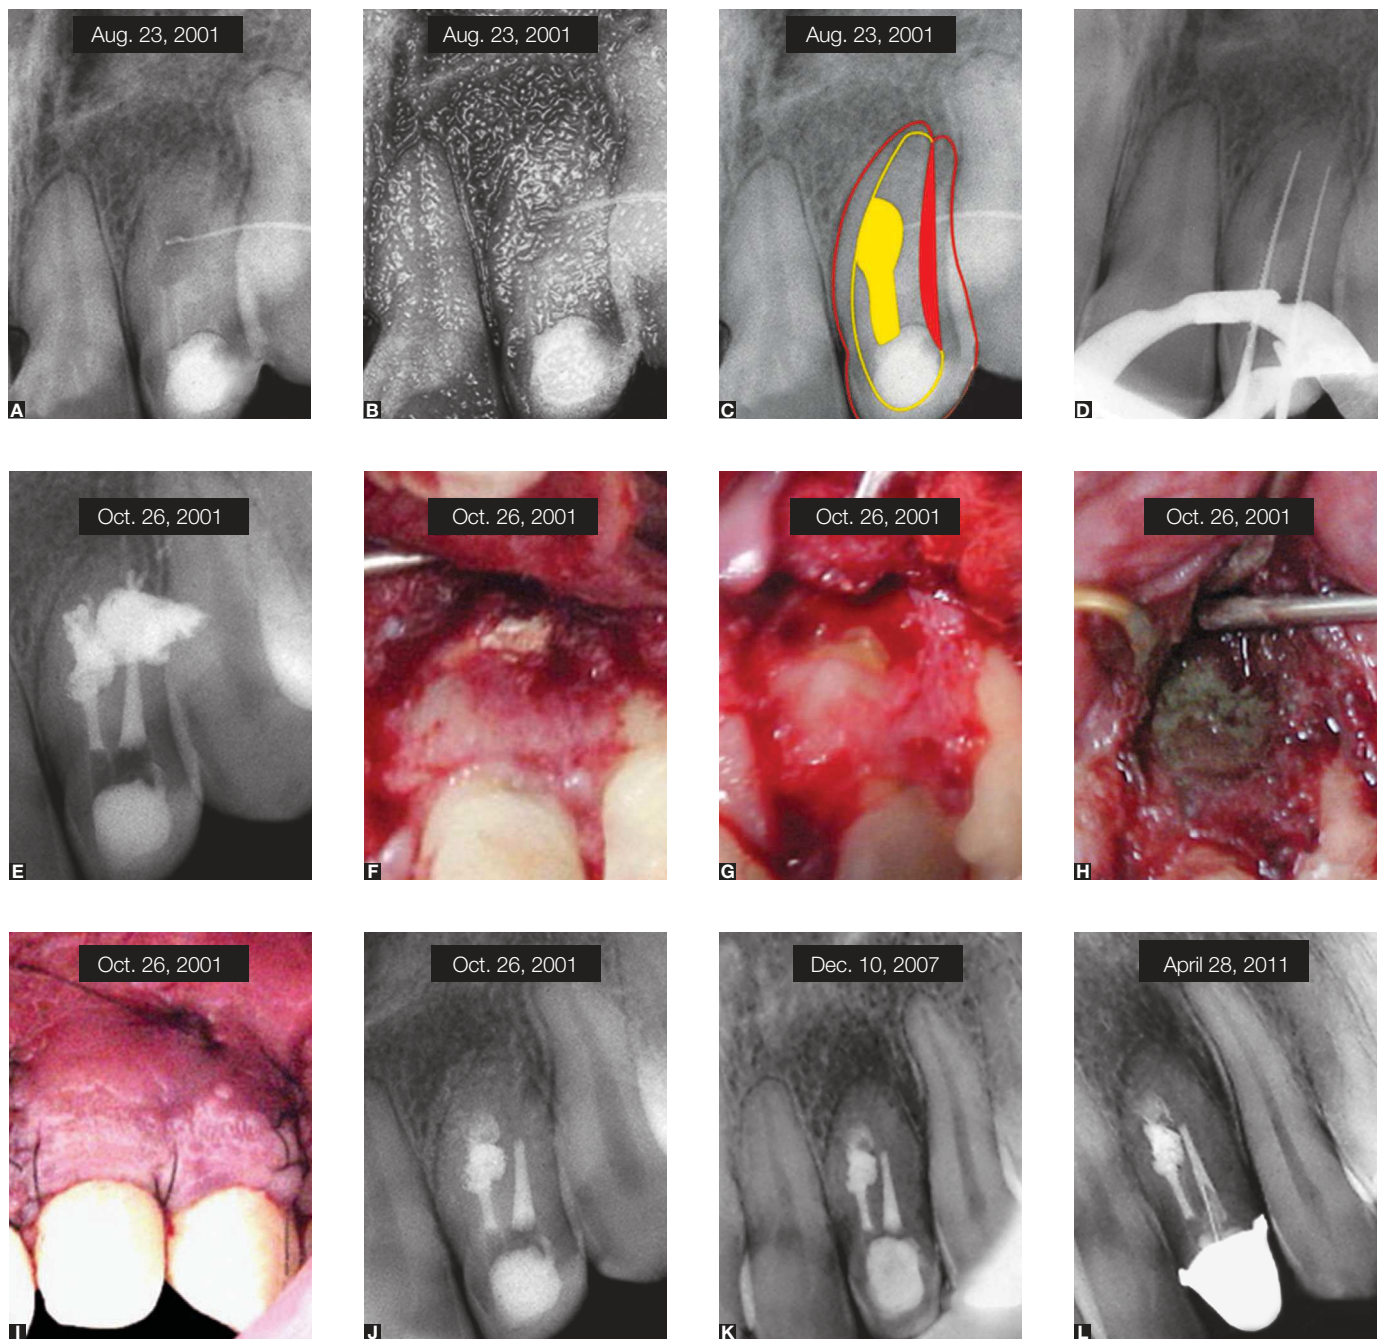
A) Initial radiograph showing fistula tracing; B) Graphic resource showing volume; C) Graphic resource defining the tooth's anomaly outline; D) Confirmation of working length; E) Extravasated obturating material; F) Transoperative photograph showing the root portion with extravasated material; G) After extravasated material removal; H) MTA inserted in the root defect; I) Tissue repositioning; J) Final radiograph; K) Follow-up radiograph; L) Follow-up radiograph.
